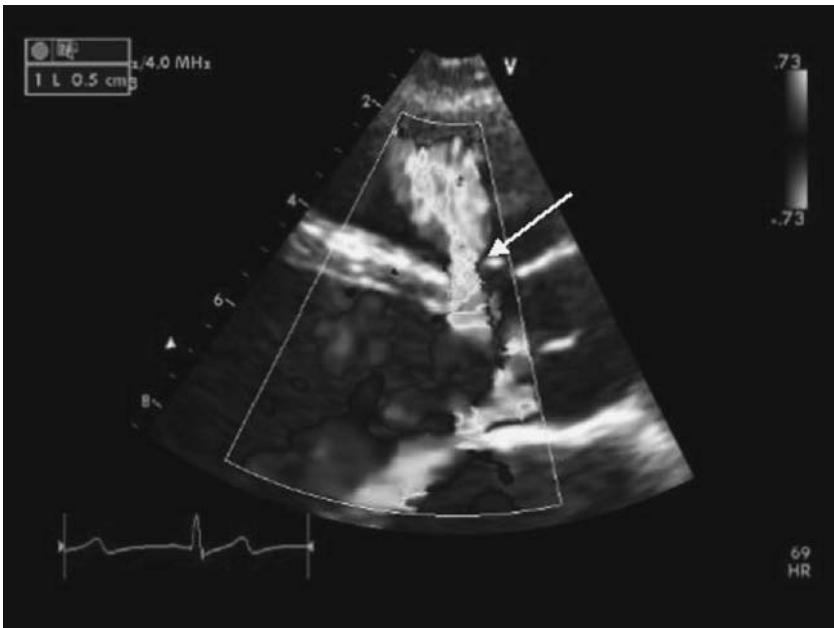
Transthoracic echocardiogram parasternal view showing Doppler color flow across a restrictive perimembranous ventricular septal defects (arrow).
